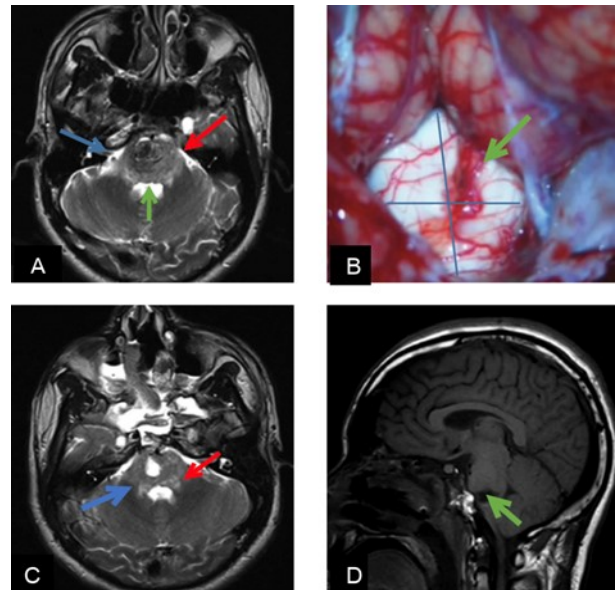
a) Preoperative axial image; b) Approach to the cavernoma (see blue and green arrows). c) Postoperative axial T2-weighted MRI (see red and blue arrows). d) Postoperative sagittal T1-weighted MRI (see green arrow).
